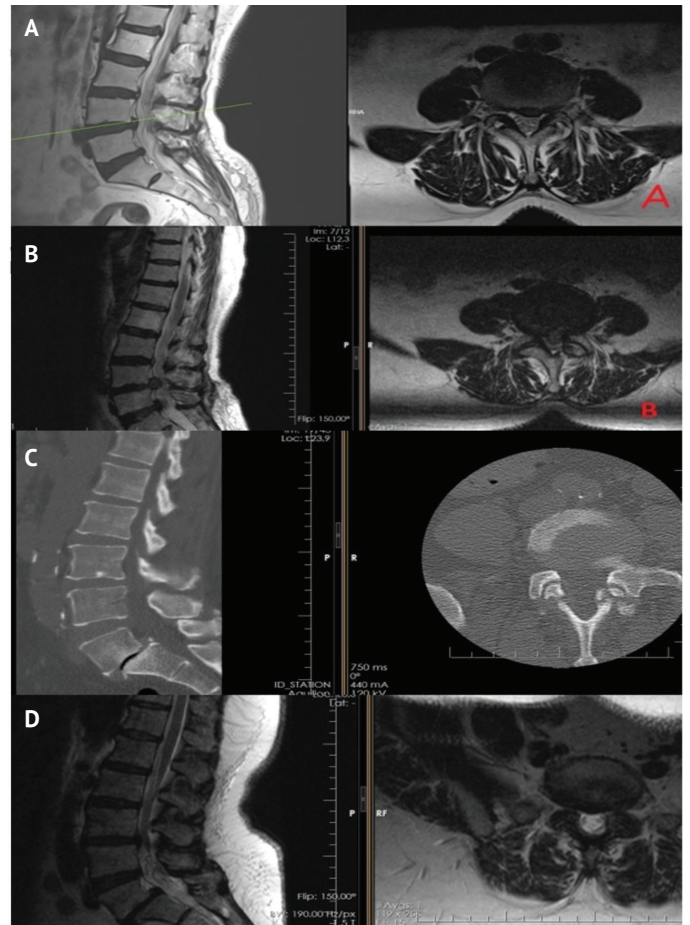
A) Preoperative (before the first surgery) T2 axial MRI of a patient with left L4-5 disc herniation. B) Preoperative (before the second surgery) T2 axial and sagittal MRI of the same patient. Disc height was reduced and facet joint was degenerated in this patient. C) Sagittal and axial lumbar CT scans show grade 2 spondylolisthesis. D) Sagittal and axial lumbar MRI scans show grade 2 spondylolisthesis
